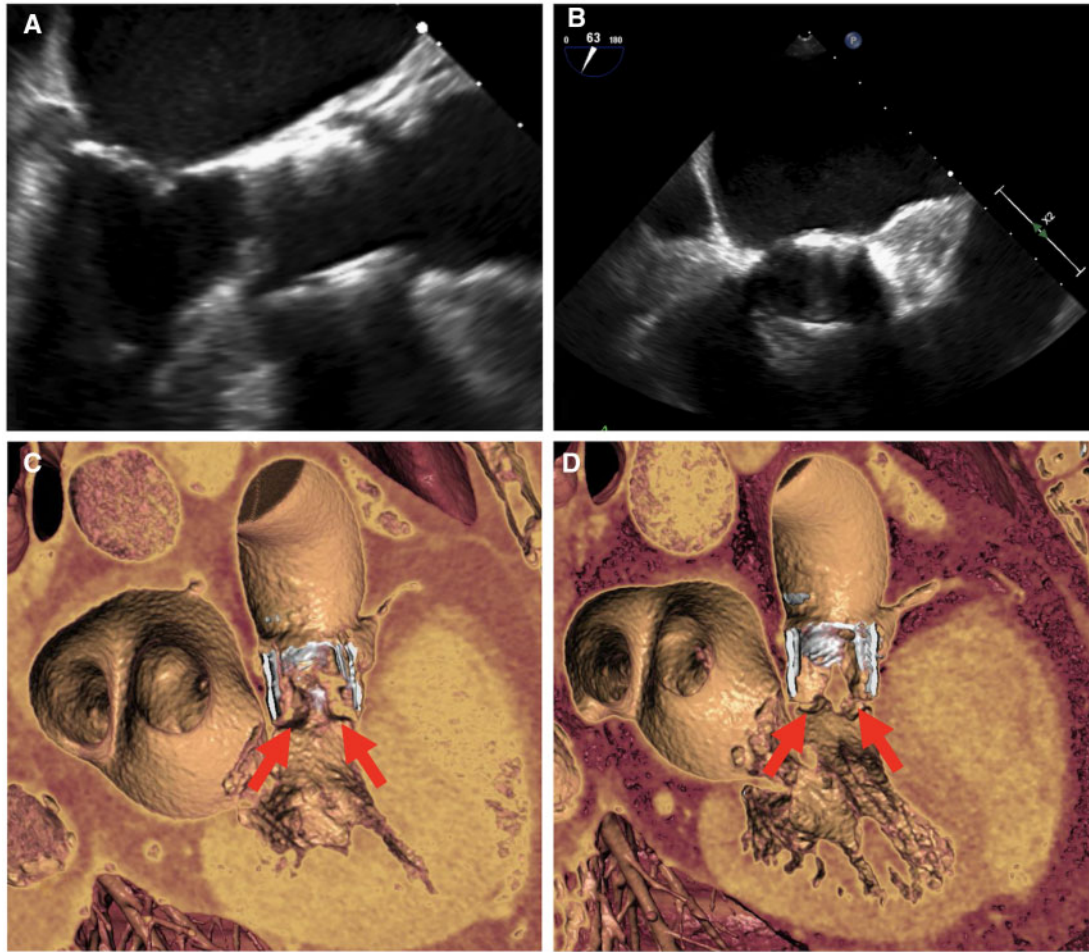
Transoesophageal echocardiography long-axis (A) and short-axis (B) images of Lotus Valve prosthesis, showing significant prosthesis artefact, limiting visualization of the leaflets, and assessment of leaflet thrombosis. Four-dimensional computed tomography images during systole (C) and diastole (D) demonstrating hypo-attenuated leaflet thickening (arrows).
